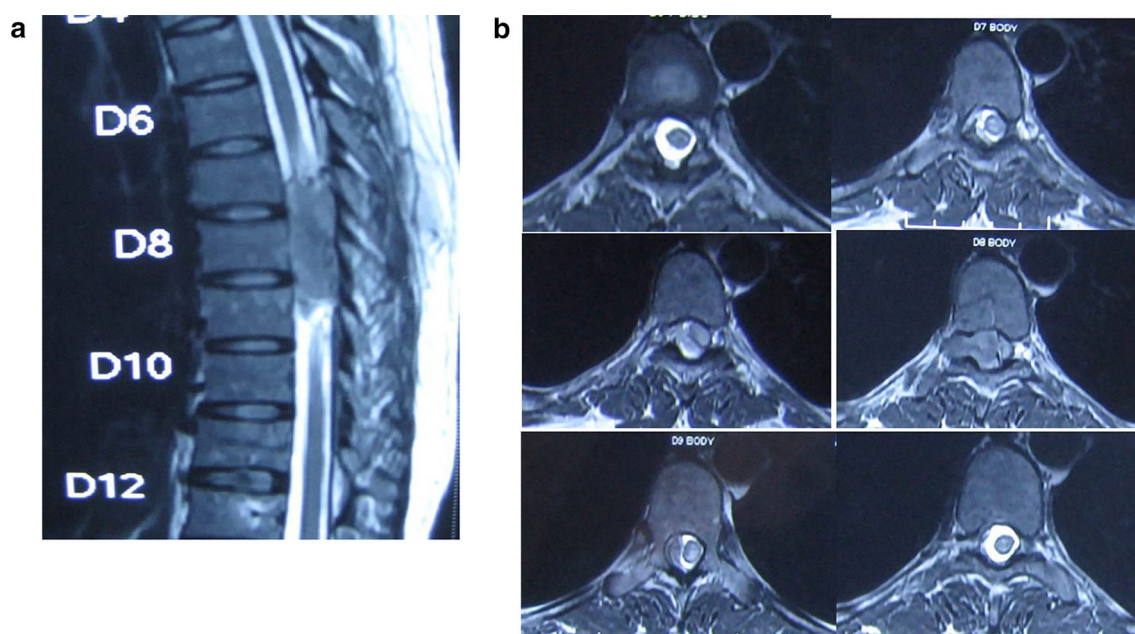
a Pre-operative midsagittal T2WI MRI image of D7–9 intradural extramedullary hemangiopericytoma with extradural extension. b Pre-operative axial T2WI MRI image at D7–9 level
